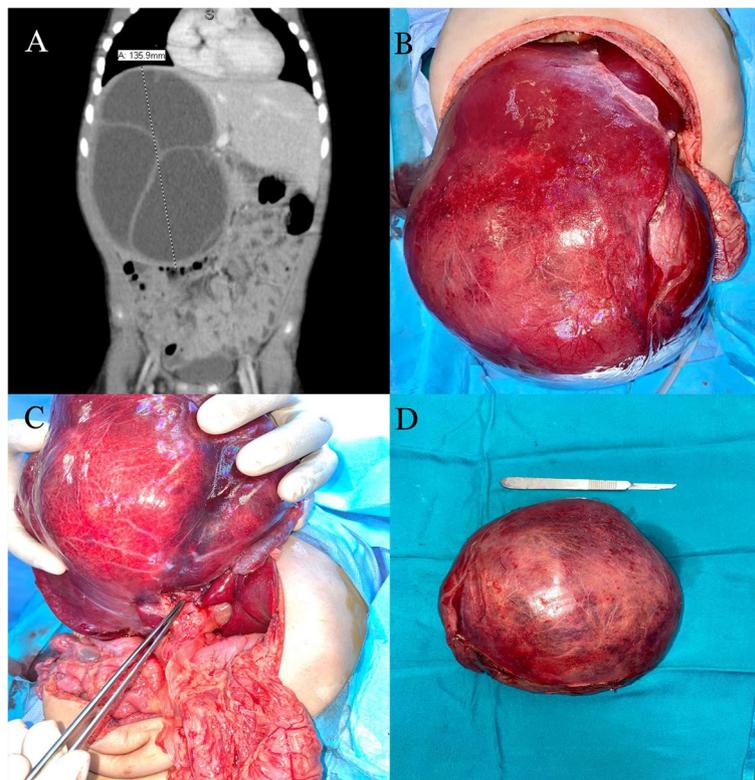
A Initial CT (coronal view) of mesenchymal hamartoma in segments V, VI, VII, and VIII (13.6 cm). B Operative photo shows tumor exposure. C Operative photo shows hilar dissection. D Right hepatectomy was performed with complete tumor resection
